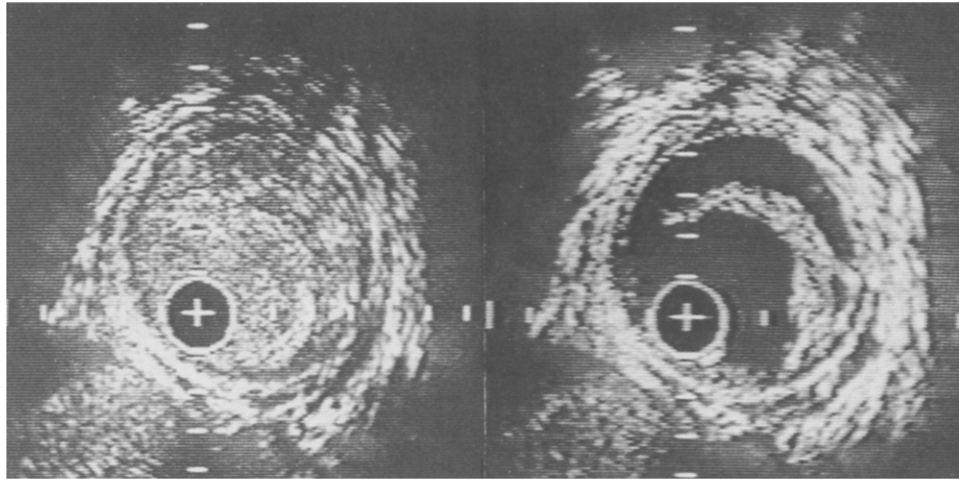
Intravascular ultrasound cross-sections obtained at the same level after balloon angioplasty of the superficial femoral artery without (left) and with (right) flushing with saline. Saline is used to eliminate the echogenic blood to clearly visualise the dissection and the free lumen area. Catheter = +; calibration = 1 mm.
